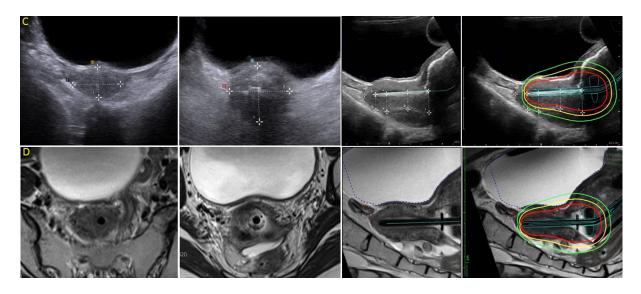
MRI and planning
